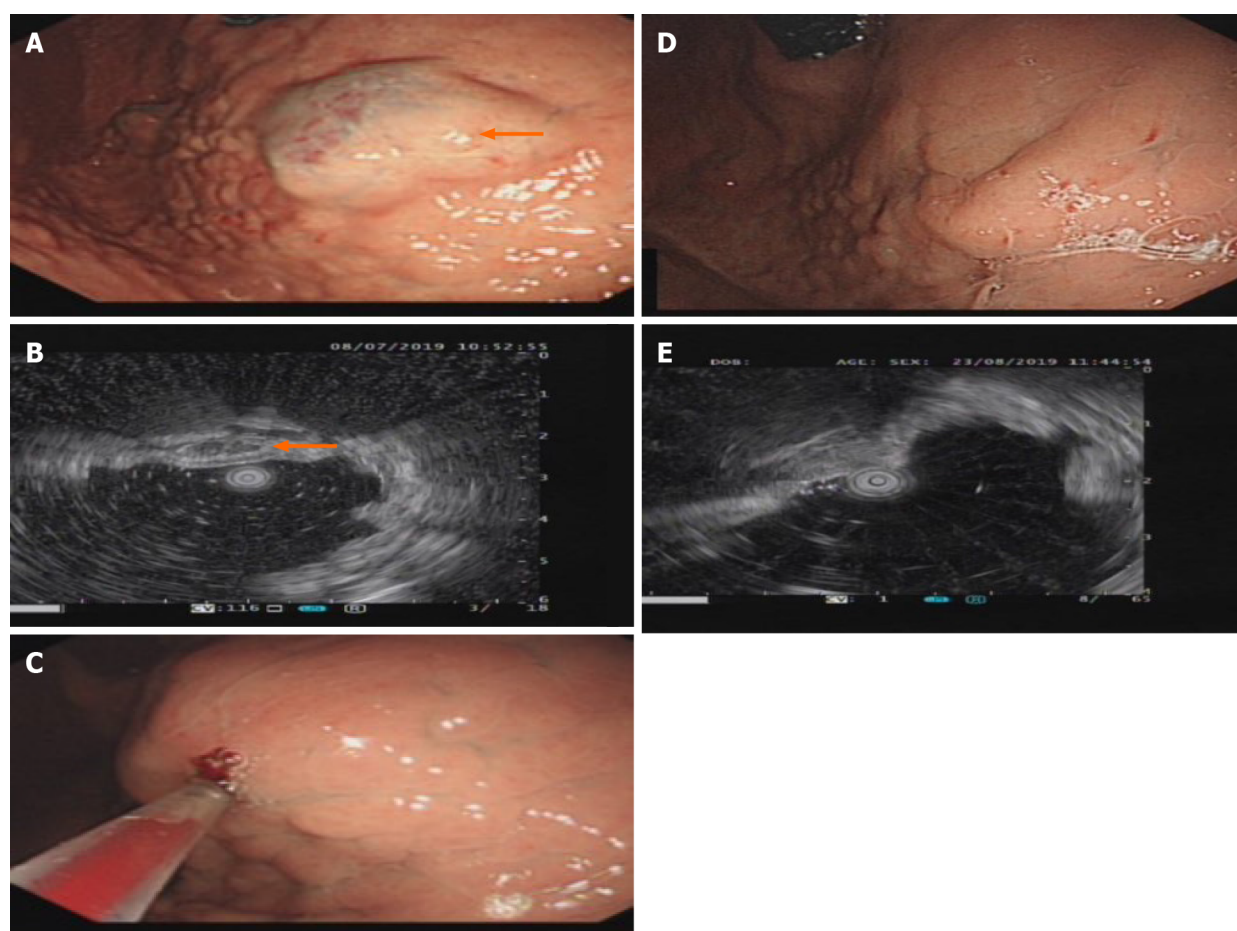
Gastroscopy and ultrasound images of the posterior wall of the bottom of the stomach. A: A 2.5 cm × 3.0 cm × 2 cm submucosal bulge of the posterior wall of the bottom of the stomach was seen on gastroscopy. The mucosa was smooth and the top of the mucosa was pale blue-purple (as shown by the arrow in the picture); B: Endoscopic ultrasound showing grid-like echoless structure with clear borders (as shown by the arrow in the picture); C: Fifteen milliliters of polidocanol was injected into the hemangioma under a transparent cap with a 25G needle endoscope; D: The submucosal bulge disappeared, and the mucosa color returned to normal on gastroscopy after treatment with polidocanol; E: The echoless structure of the lesions disappeared on endoscopic ultrasound after treatment with polidocanol.
